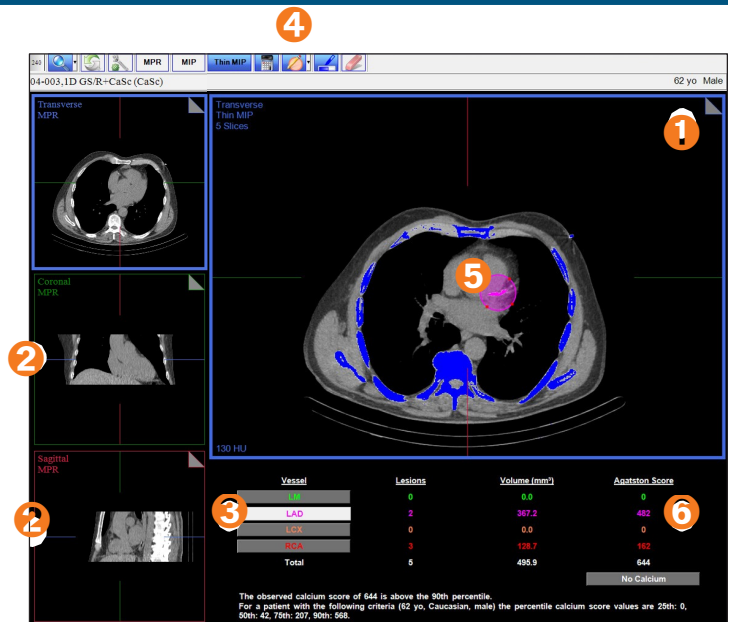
CT Volume with ROI Method
